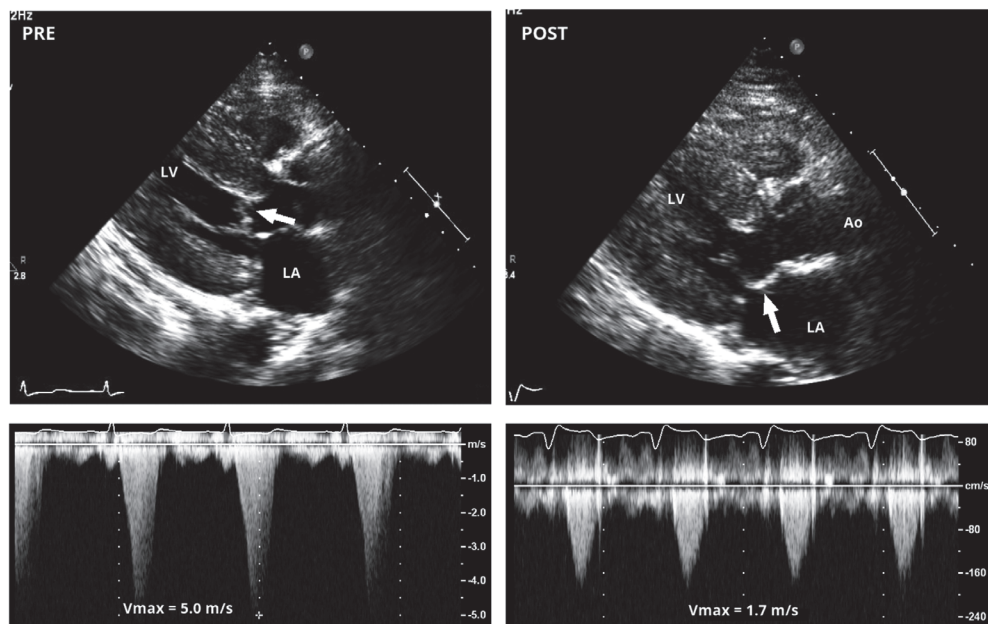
Preoperative and postoperative 2D Parasternal long-axis view (top) and Continuous Wave Doppler (bottom) echocardiograms in patient treated with combined myectomy and mitral valve leaflet extension with successful reduction of the left ventricular outflow tract gradient. Left arrow shows systolic anterior motion of the mitral leaflet. Right arrow indicates the patch in the mitral leaflet (Ao: Aorta; LA: left atrium; LV: left ventricle; PRE: preoperative; POST: postoperative).
